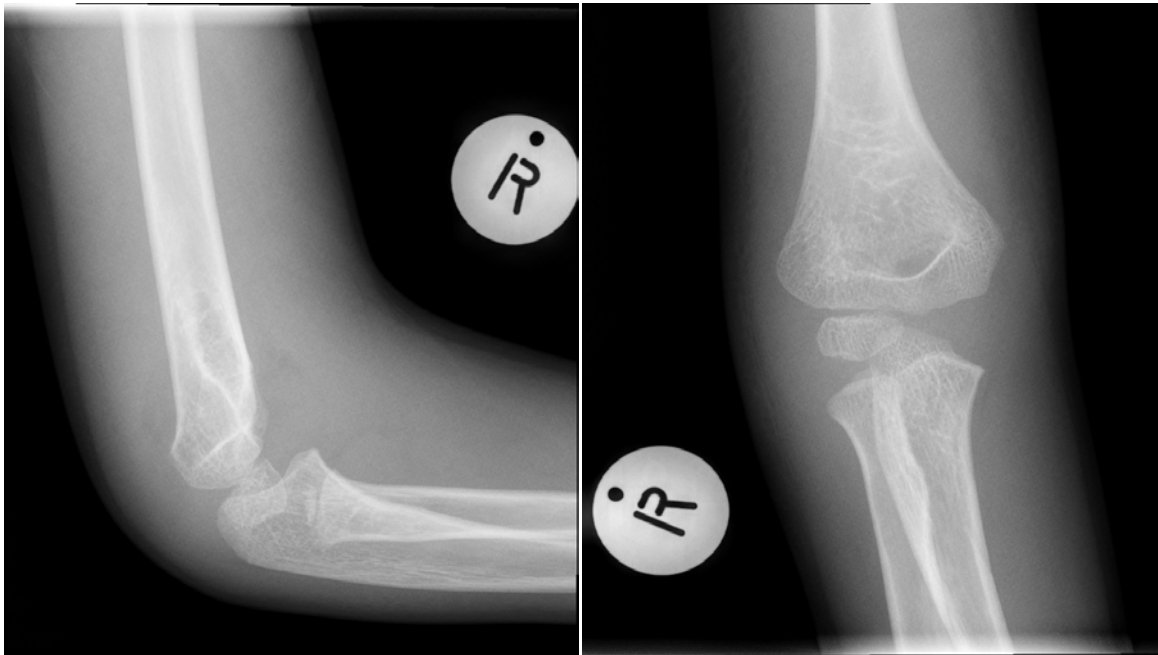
Lateral and AP radiograph of slide 7 (pre tutorial)
